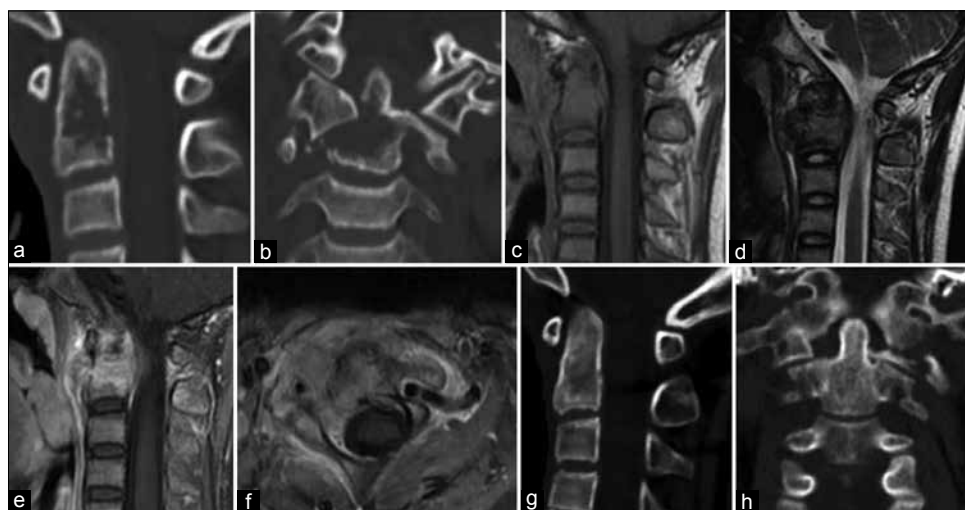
LCH of C2 in a 14-year old child. Sagittal (a) reformatted computed tomography images scan revealed that vertebrae of C2 bone destruction with penetrating into the posterior margin. Coronal (b) reformatted computed tomography images scan showed that the destruction of C2 and dislocation of C1–C2. (c) Sagittal T1-weighted images showed that C2 lesion was isointensity. T2-weighted (d) images showed that C2 lesion was isointensity. On sagittal (e) gadolinium-enhanced T1-weighted image showed the significant enhancement. Axial (f) showed the dural sac was compressed with narrowing of spinal canal. Computed tomography re-examination carried out 2 years later showed that bone destruction of C2 was repaired on sagittal (g). Coronal (h) images showed repairment in C2
